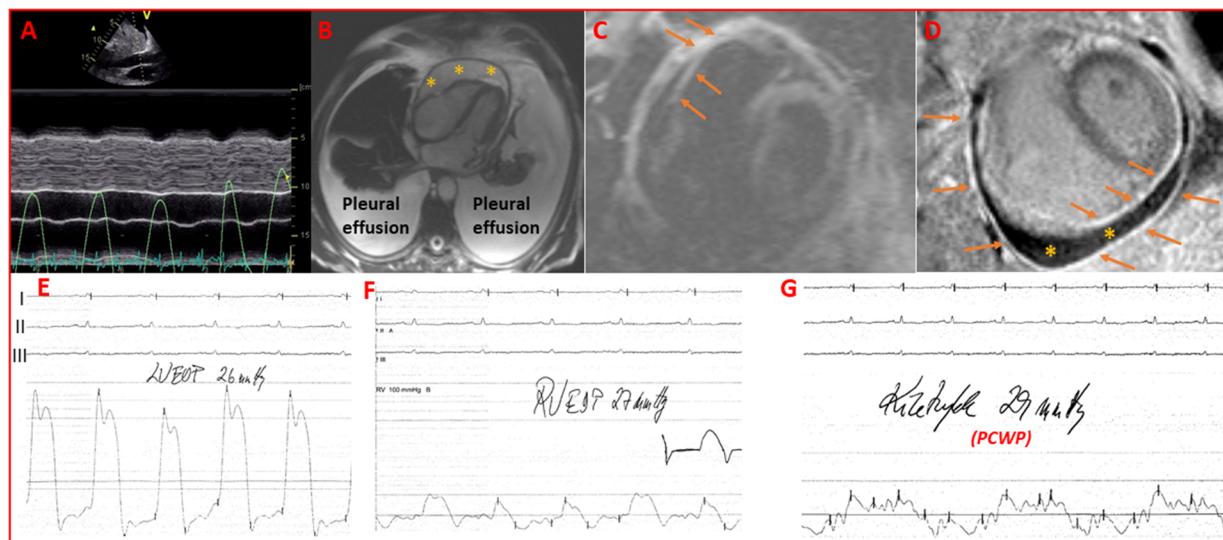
(A) A wide inferior vena cava with restricted respiratory diameter variation. (B) MRI of the heart showing pericardial effusion (asterisks) and bilateral pleural effusions. (C, D) MRI displaying thickened and oedematous pericardium (arrows) enclosing the heart and the pericardial effusion (asterisks). (C) A short-axis T2-weighted short-tau inversion recovery (STIR) image and (D) a corresponding late gadolinium enhancement image. (E–G) Invasively measured pressure curves: (E) left ventricular end-diastolic pressure of 26 mm Hg, (F) right ventricular end-diastolic pressure of 27 mm Hg and (G) pulmonary capillary wedge pressure (PCWP) of 29 mm Hg. End-diastolic pressures are equally elevated in all cardiac chambers.
